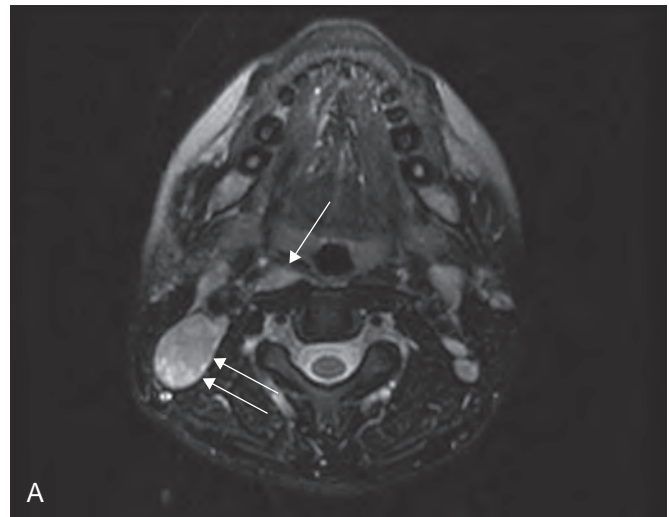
Nasopharyngeal carcinoma, nonkeratinizing undifferentiated type. (A) Computed tomography study demonstrating thickening of the nasopharyngeal region (arrow) and an enlarged cervical lymph node (double arrow). (B) The syncytial clusters of malignant epithelium are infiltrated by benign lymphocytes. (C) In situ hybridization for EBER-1, a small nuclear RNA encoded by Epstein-Barr virus.
